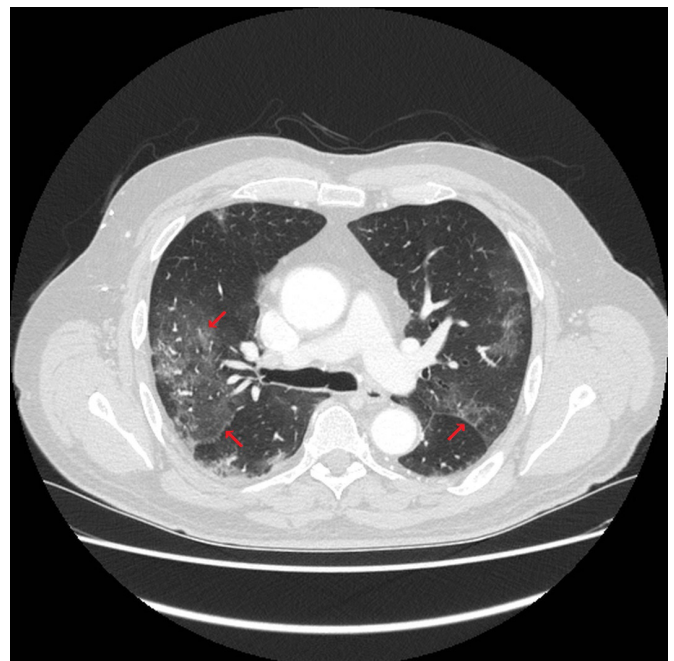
CT scan in axial plane showing ground glass opacities (arrows).
